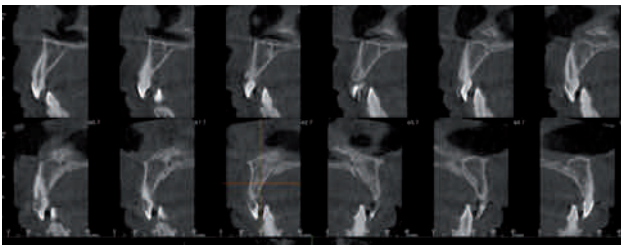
CBCT sagittal sections, where the resorptive extent of the lesion is seen.
